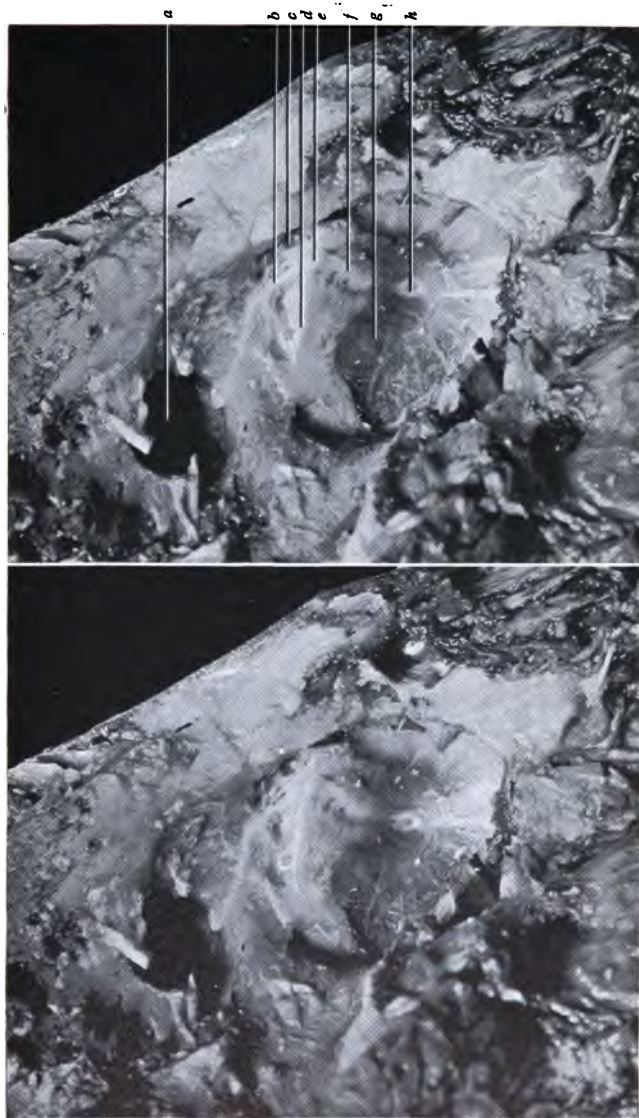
RIGHT TYMPANIC MEMBRANE, ETC., REMOVED POST-MORTEM FROM A CASE OF SEROUS CATARRH OF THE MIDDLE EAR: VIEWED FROM THE OUTER ASPECT. $\times 2\frac{1}{2}$. (Prepared and photographed by the Author.)
